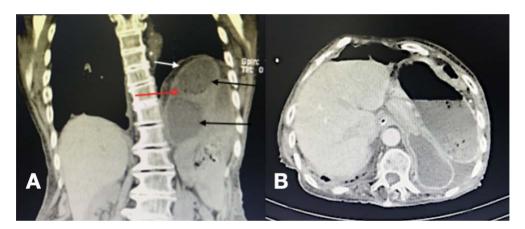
Computed tomography scan. Panel A: coronal view showing gastric malrotation with antrumpylorus elevation causing the obstruction and looking like gastric volvulus. Also, presence of mild left pleural effusion. Black arrows: stomach with significant fluid content; red arrow: mural cystic neurofibromatosis; white arrow: left hemidiaphragm elevation. Panel B: axial view. Small amount of fluid adjacent to the stomach. No pneumoperitoneum.
